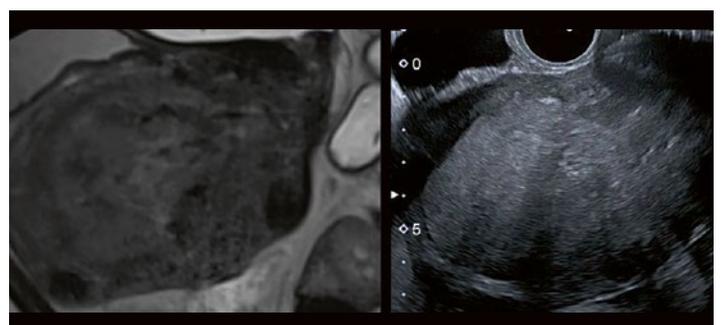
MRI and ultrasound sections of the tumour.
